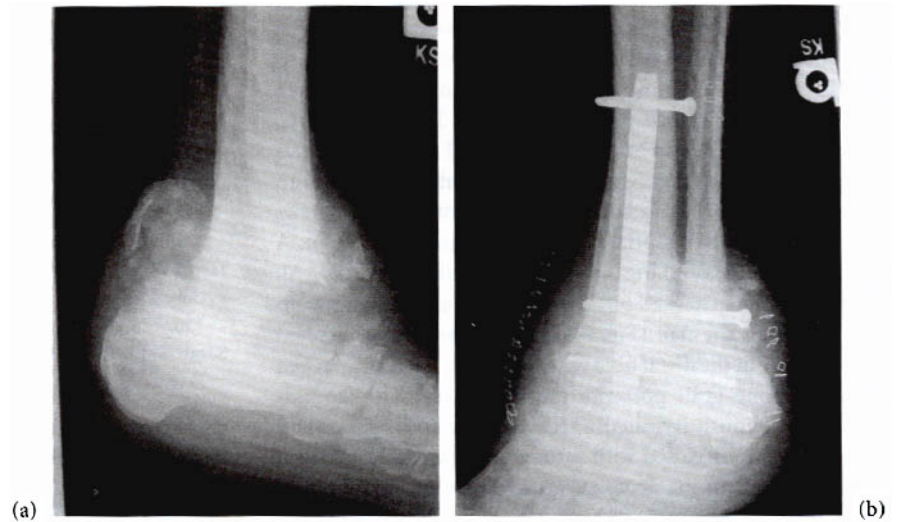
(a) Lateral radiograph reveals extensive destruction of the left ankle joint with disintegration of the talus and fragmentation of bone. (b) Postoperative radiograph of the left ankle following tibiocalcaneal fusion with the intramedullary nail and interlocking screws in place. (c) Long-term follow-up. Clinical appearance of the left foot and ankle 5 years after surgery.
